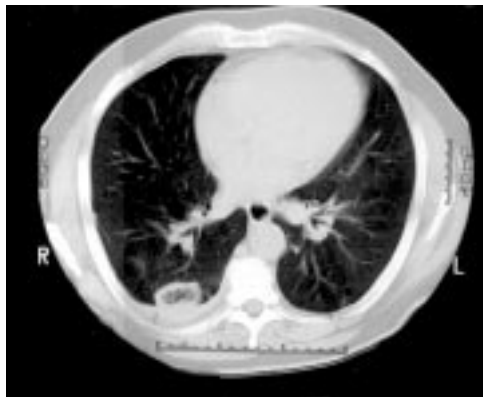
Chest CT scan four months later showing a new area of consolidation with cavitation in the right lower lobe. Both the opacities proved to be pulmonary infarcts secondary to obstruction of pulmonary arteries by squamous cell carcinoma.
